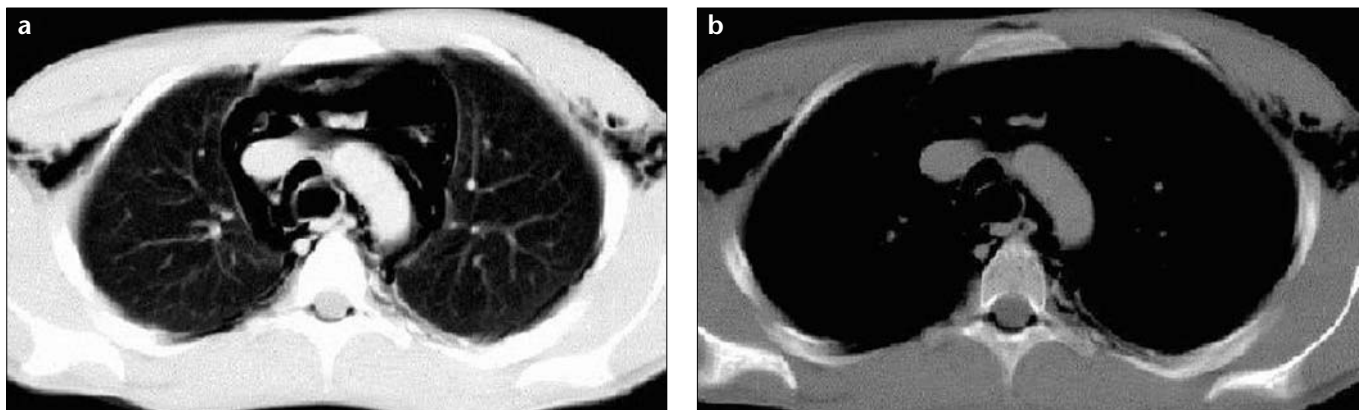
a, b. Transverse pre-contrast CT images at the arcus aorta level demonstrates pneumomediastinum and epidural pneumatosis on parenchymal (a) and mediastinal (b) window settings.
